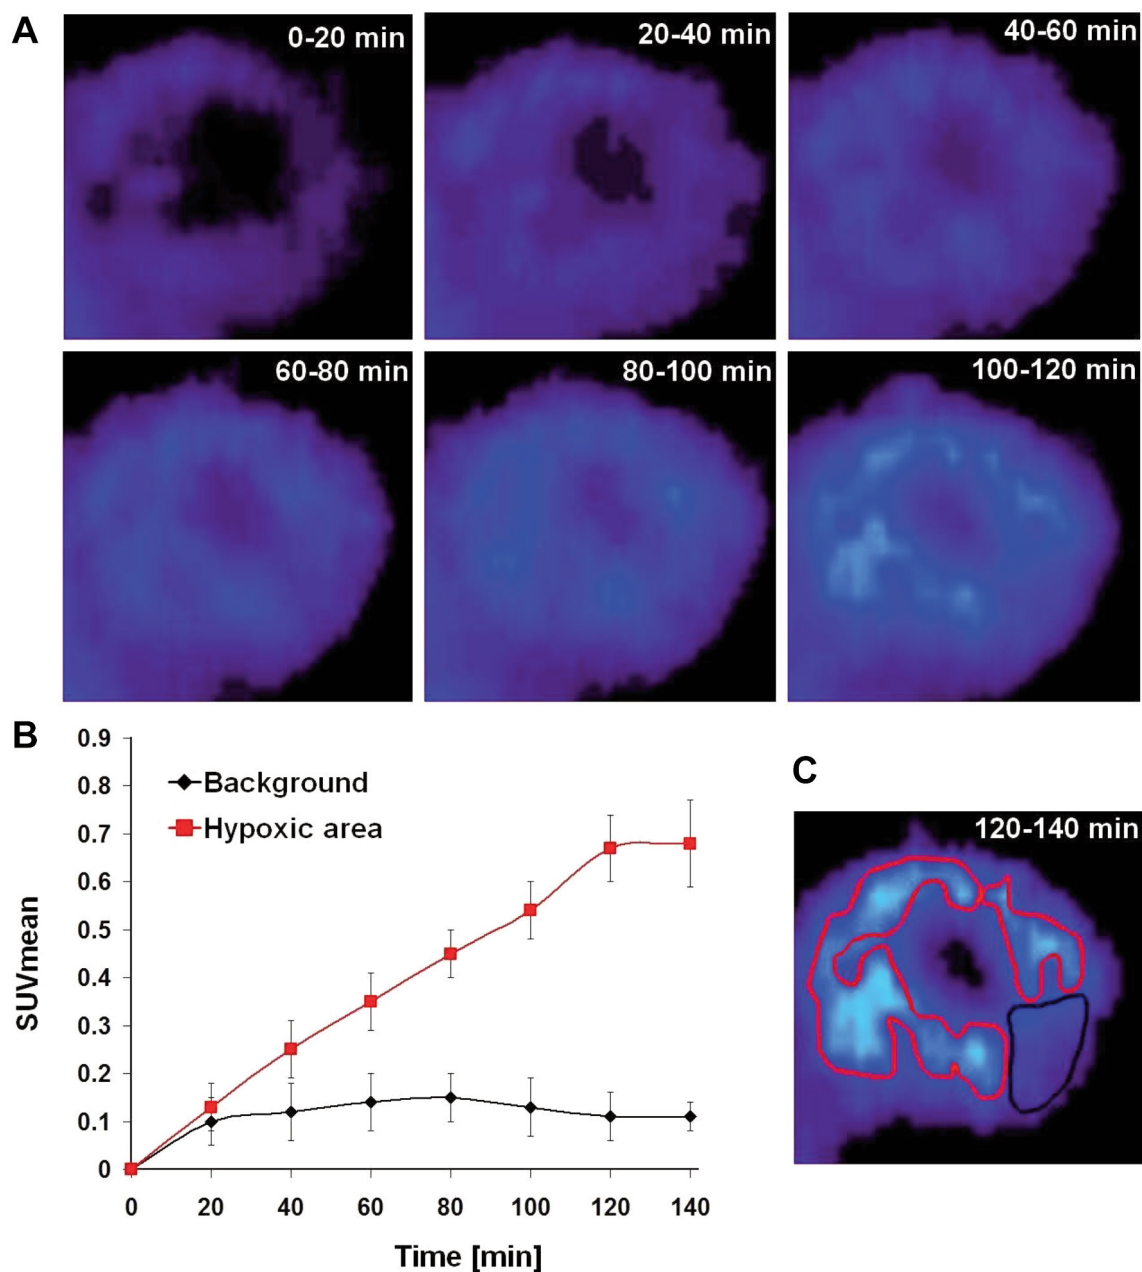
Temporal kinetics of the Fluorine-18 fluoroazomycin arabinoside (^{18}F]F-FAZA) accumulation in the hypoxic and non-hypoxic regions of the investigated tumors. ^{18}F]F-FAZA accumulation in a representative tumor xenograft (KB-3-1) at 20 min intervals from the start of the radiotracer injection (0 min) until the end point (140 min) of the dynamic acquisition (Panel A and C). Temporal uptake kinetics of ^{18}F]F-FAZA in the hypoxic (red line) and non-hypoxic (black line) regions of the investigated tumors (Panel B). SUV: Standardized uptake value.
